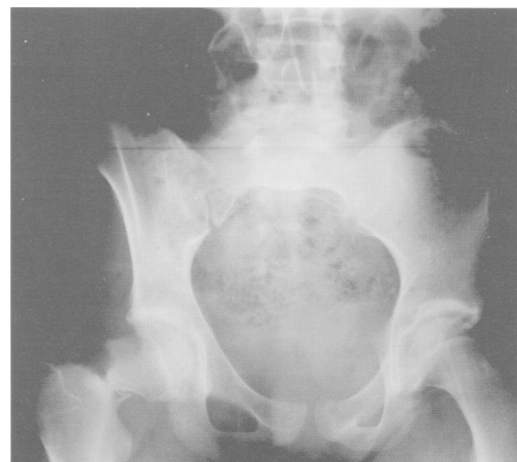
Anteroposterior radiograph of the pelvis showing a displaced compression type stress fracture of the right neck of femur.
